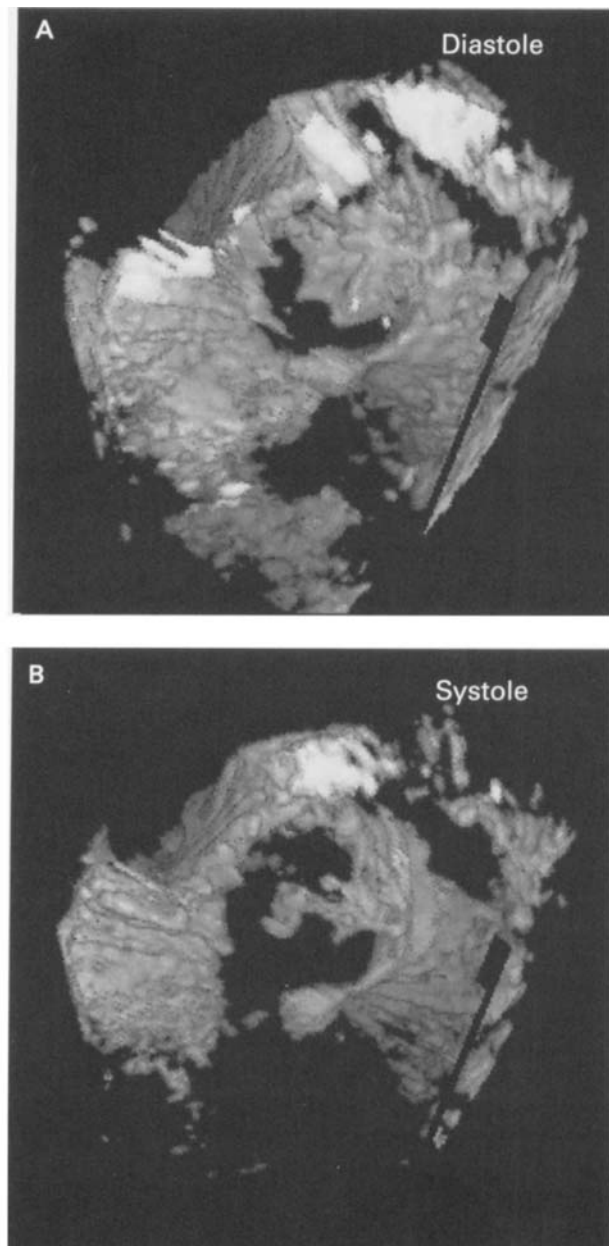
Three-dimensional transoesophageal echocardiographic volume rendered image of a normally functioning Medtronic Hall valve in the aortic position in (A) diastole and (B) systole. In systole the central hinge and part of the disc can be seen. In diastole the tilting disc seals of inner ring. Because of the settings used, this cannot entirely be seen as they were optimised for the central hinge part. The margins of the inner ring appear less irregular than in Figure 7.4.
